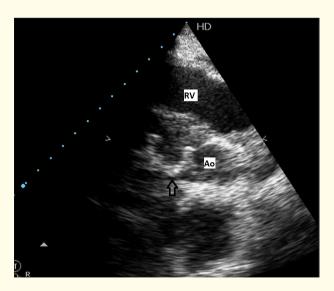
Short axis view at aortic valve level of transthoracic echo showing bioprosthetic valve at tricuspid position (black arrow).
